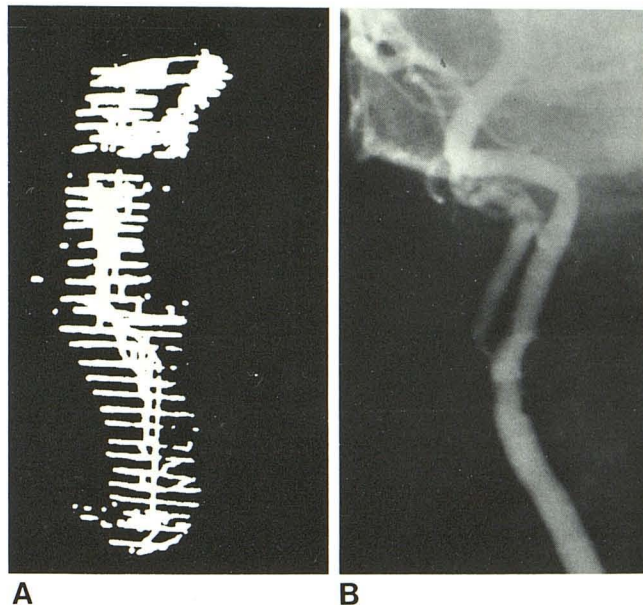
Error in localization in 79-year-old woman with previous left hemisphere stroke and bilateral bruits. Doppler examination on right was thought to indicate hemodynamically significant stenosis of internal carotid. A, Sonogram. Branch vessels were nearly superimposed, making imaging difficult. B, Anteroposterior arteriogram. Severe external carotid stenosis and relatively normal internal carotid, which was superimposed on external carotid in coronal plane. Error of localization might have led to patient mismanagement.
